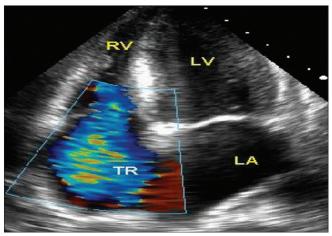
Tricuspid regurgitation on echocardiography
